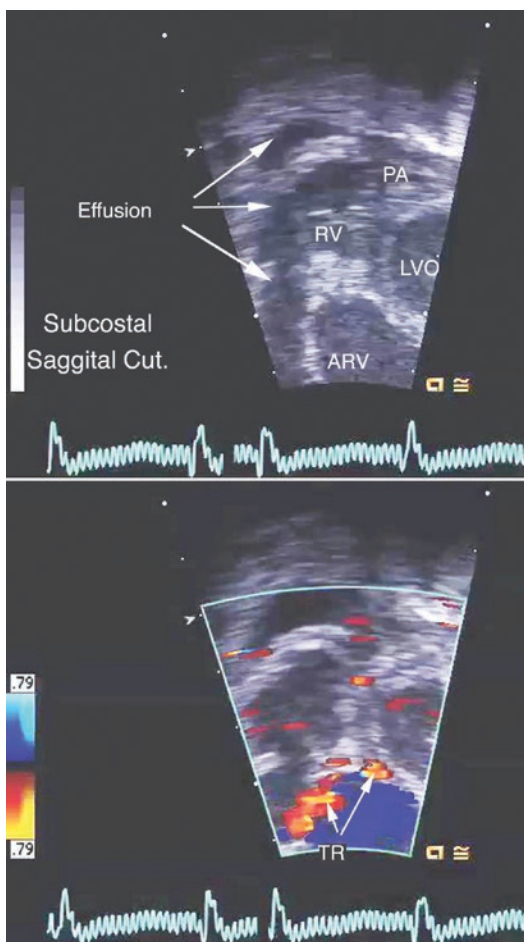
This subcostal sagittal-cut image series shows gray scale images above with Doppler color flow superimposition below. These are the orthogonal images, taken from Fig. 13.18 top right, and show how small the true right ventricle can be when imaged together from these orthogonal views. Anterior to the right ventricle is a pericardial effusion. The tricuspid leaflets are thickened and rolled, and divide the right ventricle into an atrialized portion (ARV) and a functional portion (RV). The pulmonary valvar leaflets are also thickened and were held closed on the real-time image with blood flow supplied to the pulmonary arteries exclusively from the arterial duct. *The bottom color frame shows two jets of tricuspid regurgitation (TR and arrows) arising from different coaptation points of the tricuspid valve*
